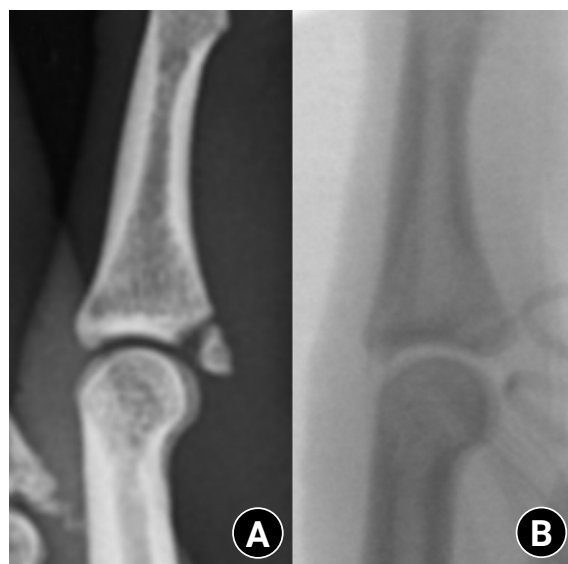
Radiographs of a middle phalanx avulsion fracture. (A) Initial fracture. (B) Reduction after open reduction.
